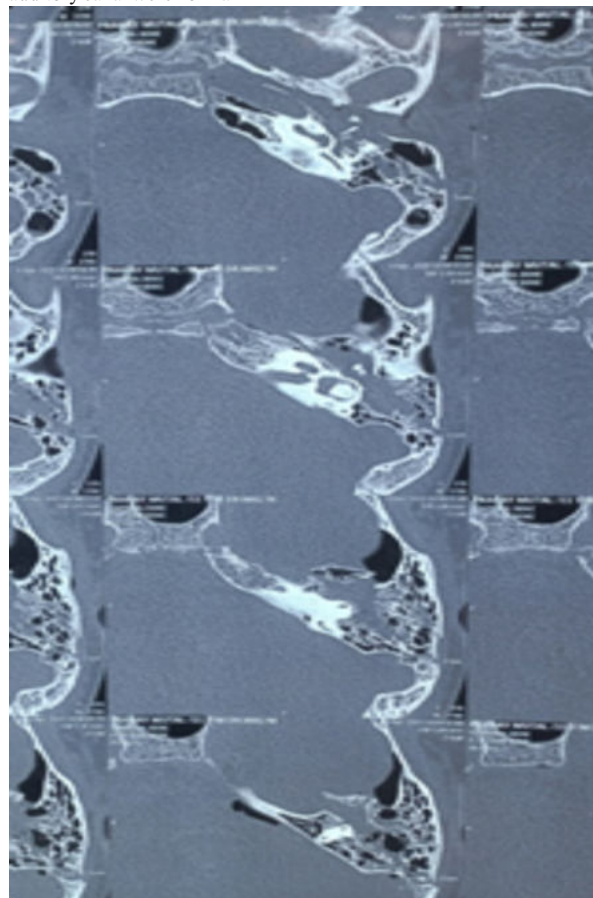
HRCT Of The Left Temporal Bone
